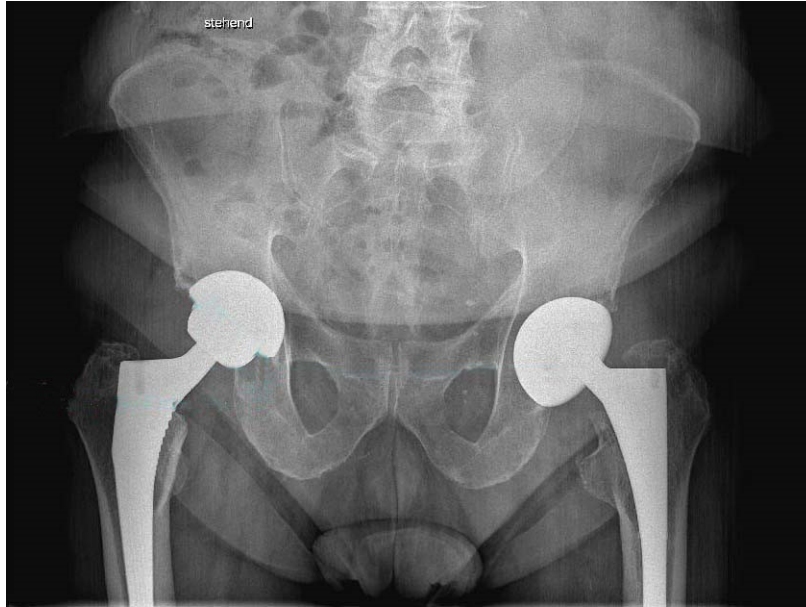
The figure shows the X-ray of patient one in anterior-posterior view
